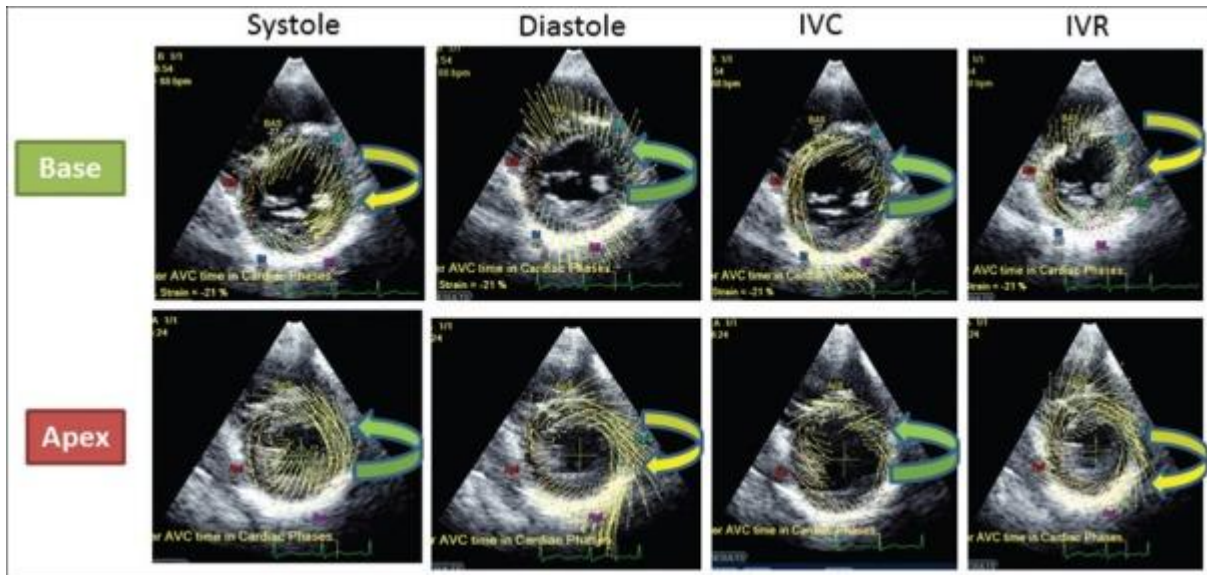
Echocardiography is used to display the twisting of the cardiac wall during contraction.
